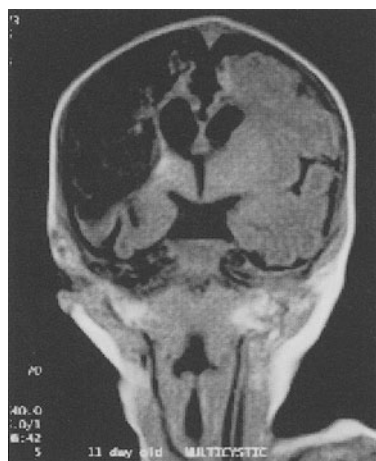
A T1-weighted image (TR 540, TE 15) of encephalomalacia from a Siemens 0.2-T MR system. (Margareta Arens, MD, St. Barbara Klinik, Hessen, Germany, used with permission)
